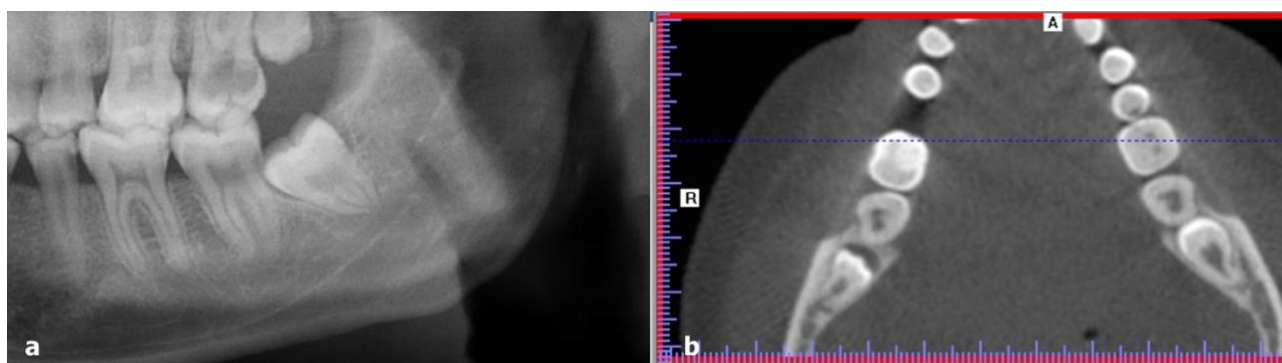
(a) Panoramic view of distal caries on tooth no. 38, (b) CBCT view of tooth no. 38; no distal caries were observed.
